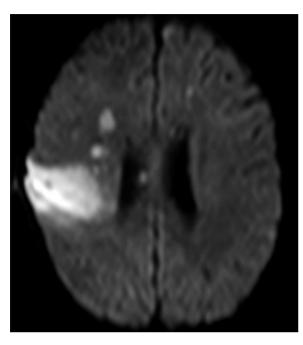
On diffusion weighted MRI, increased signal intensity in the right middle cerebral artery territory, centrum semiovale, and in the dorsal part of the head of the left caudate nucleus were noted suggestive of infarction in the right MCA territory.
